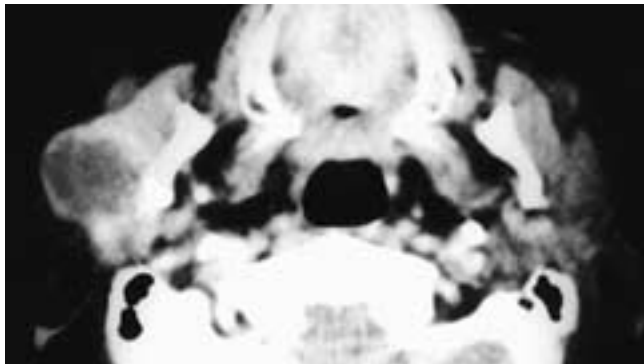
Axial contrast-enhanced CT scan shows a necrotic right parotid mass that has infiltrated the entire gland and the adjacent masseter muscle. This patient had an SCC of the parotid gland.
